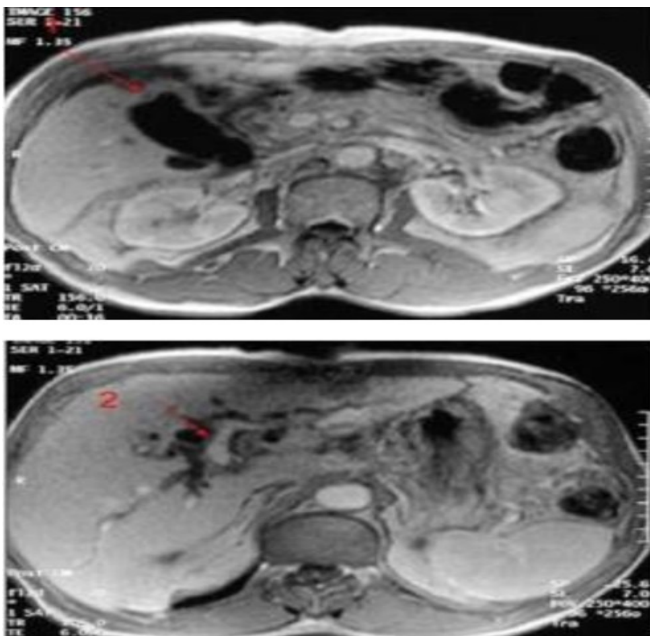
Axial MRI sections in FSE T2-weighted sequence after gadolinium injection show a thickened gallbladder, particularly at the fundus (1). A heterogeneous mass is noted in segment IV. The intrahepatic bile ducts are dilated (2)
